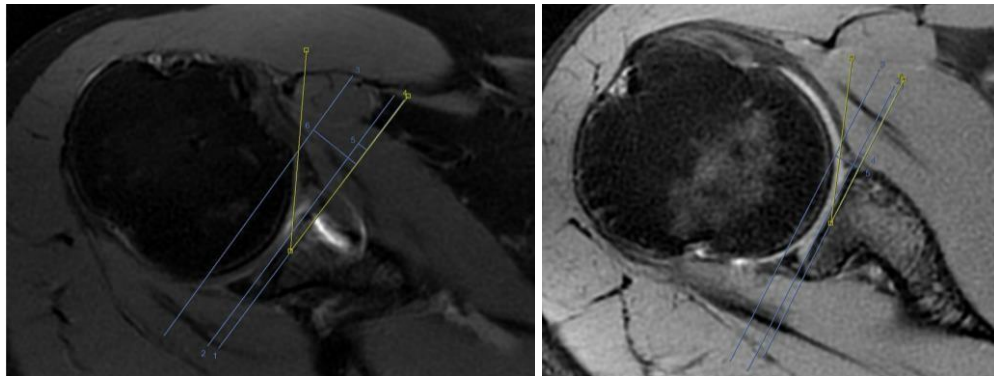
MRI T2-weighted trans axial slices showing the quotient of labral height (LH) to glenoid height (GH) was used to create the Labrum Glenoid Height Index (LGHI) (GH). The angle between the tangent to the lowest section of the glenoid Cavity (I) and the segment between the tip of the maximal labral height and the lowest portion of the glenoid cavity was designated as the labral Slope (II). These characteristics were assessed using T2-weighted trans axial slices for the anterior region and coronal slices for the inferior portion
